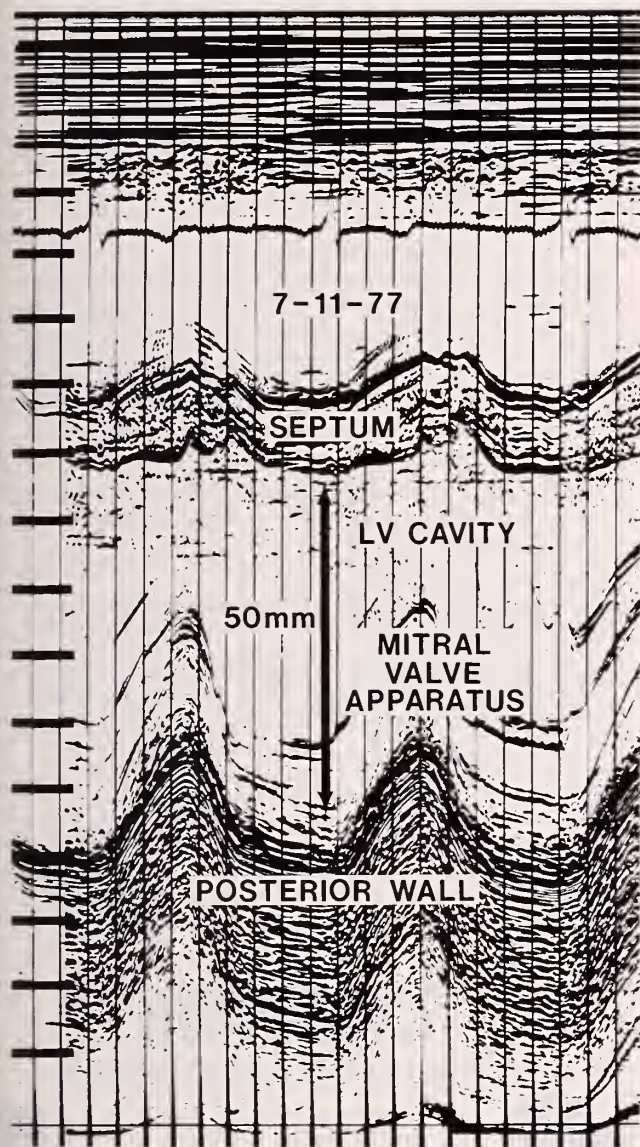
Postoperative Echocardiogram.
